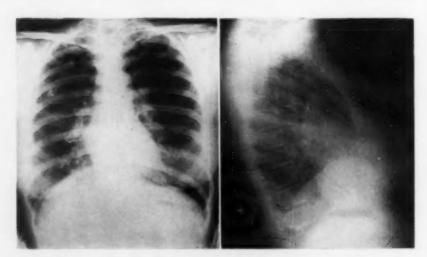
Chest roentgenogram of 32 year old woman with sarcoidosis, confirmed by scalene node biopsy. The total lung capacity was 40.7 per cent of normal predicted. Residual air was 28 per cent of total lung capacity.
